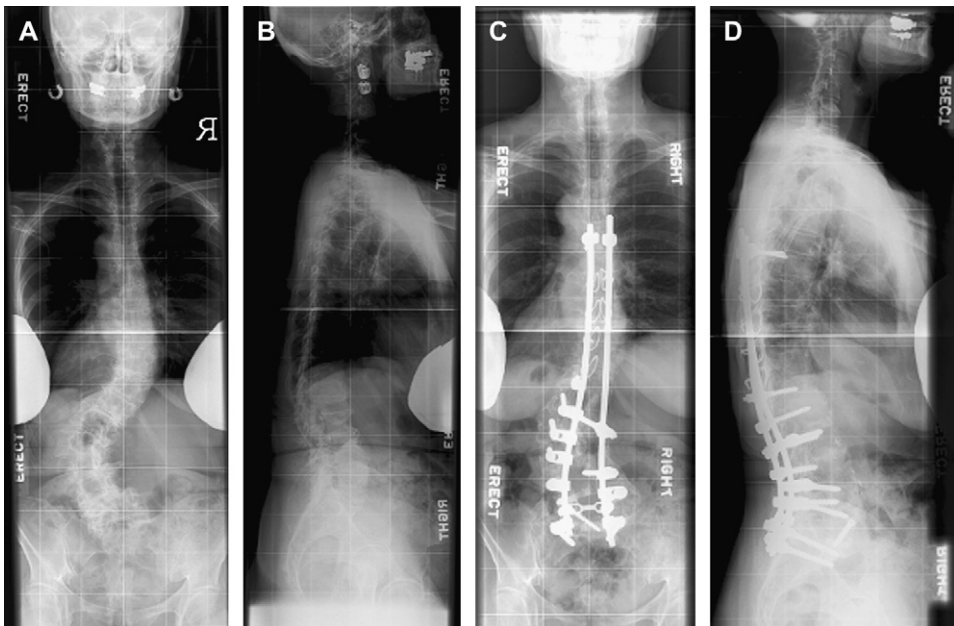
A 72-year-old woman presented with chronic lower back pain, left lower extremity radiculopathy, and progressive deformity refractory to conservative treatment. Preoperative AP (A) and lateral (B) radiographic views show a lumbar curve of 65.6° . The patient underwent two-stage surgery with anterior fusion from T12 to the sacrum, followed by lumbar decompression and posterior spinal fusion from T7 to the sacrum. Two-year postoperative AP (C) and lateral (D) radiographic views show a solid fusion mass and good coronal and sagittal balance.
